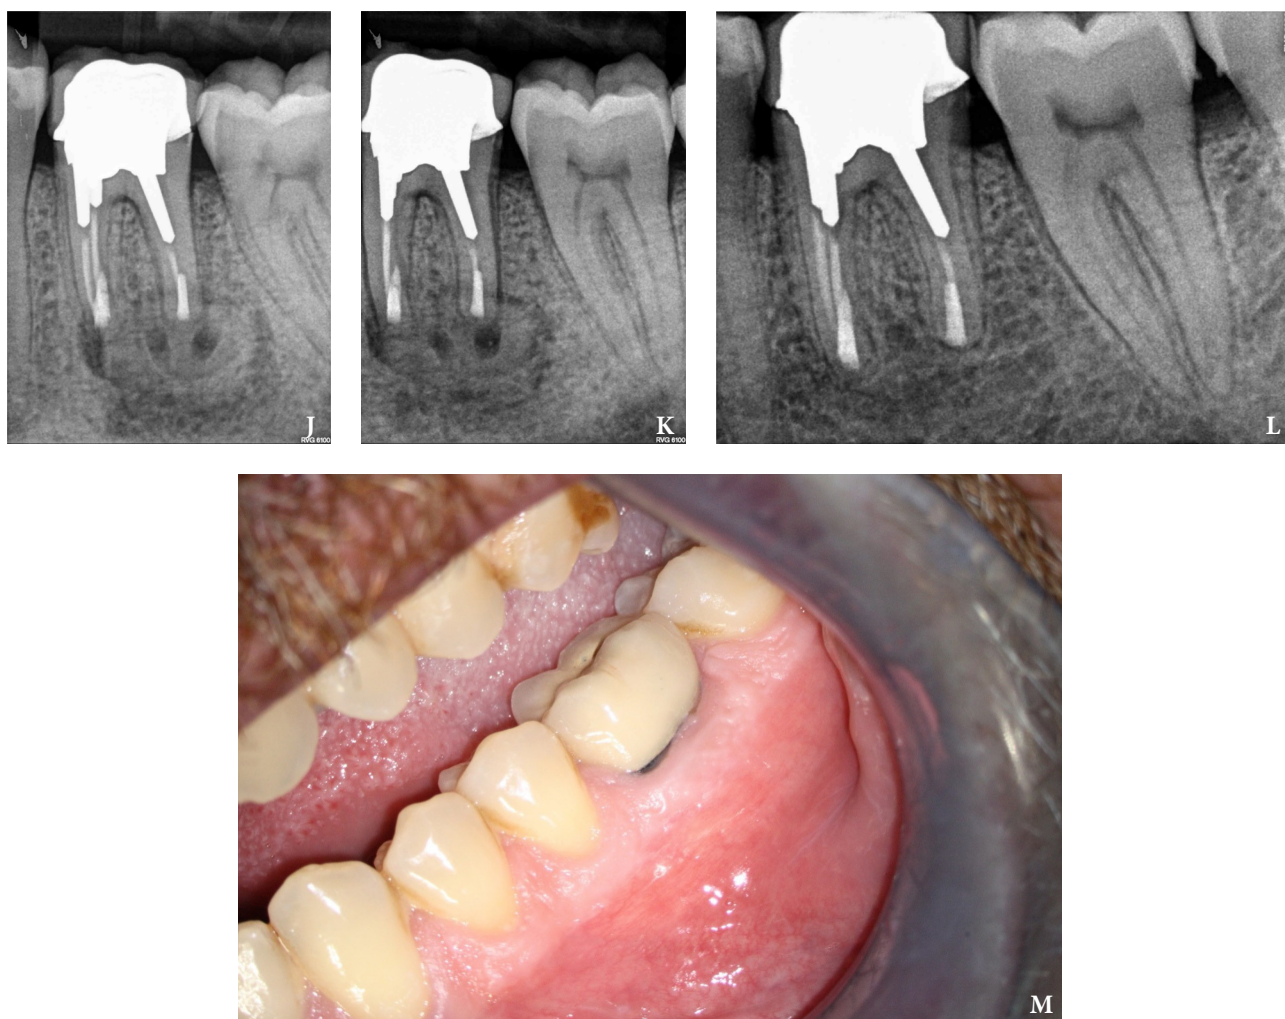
(continued). Follow up after 3 months (J, K). Follow up at three years: Radiographic (L) and clinical (M) examination showing complete healing.
